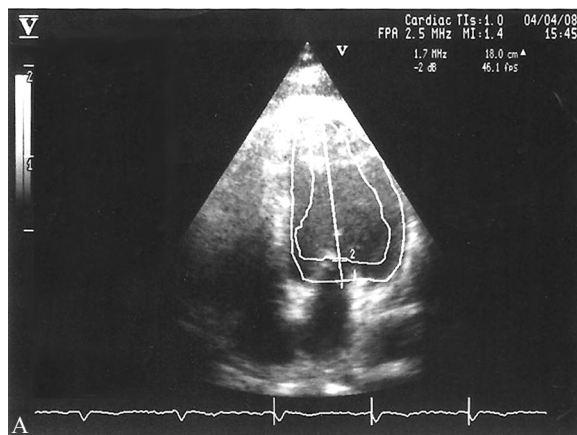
and 1B: ED and ES volume traces demonstrate both apicobasal (ED lower MA level on the fig. 1a and ES upper MA level on the fig. 1b) and radial (inner cavity border of ES trace) LV contractility on the 4 chamber apical 2 dimensional echocardiographic view of a hypertensive patient with EF of 61%.
